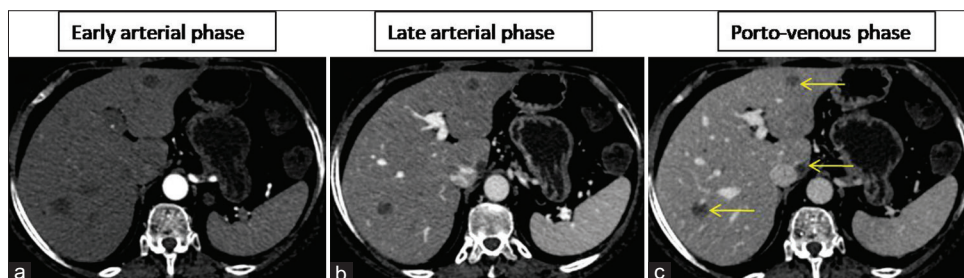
Triple-phase contrast-enhanced computed tomography images of the abdomen. (a-c) show multiple hypoattenuating lesions in both lobes of the liver with predominant peripheral enhancement
